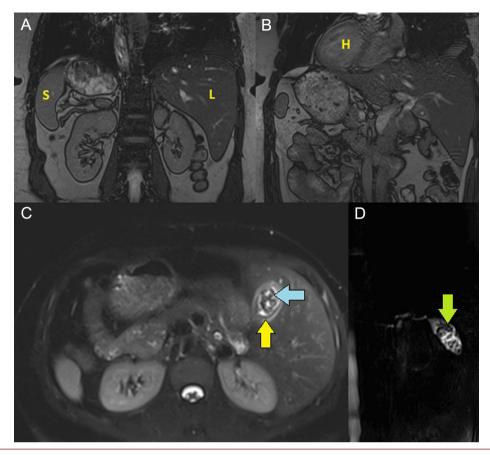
In the coronal plane T2-weighted magnetic resonance image, the spleen (S) is located on the right, and the liver (L) is located in the left upper quadrant of the abdominal region (A). In another coronal image in the same sequence, the patient was observed with a right-sided heart (B). In the axial T2-weighted fat-saturated Half fourier Single-shot Turbo spin-Echo (HASTE) sequence, the thickening of the gallbladder wall (yellow arrow) and low signals depicting gallbladder stones (blue arrow) were indicated (C). Three-dimensional images with the T2-weighted HASTE sequence depict the gallbladder with stones in the lumen (green arrow) (D).
